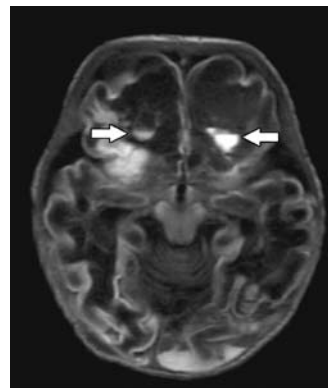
Brain MRI of family IV, patient 1, showing hemorrhage and periventricular calcifications.
